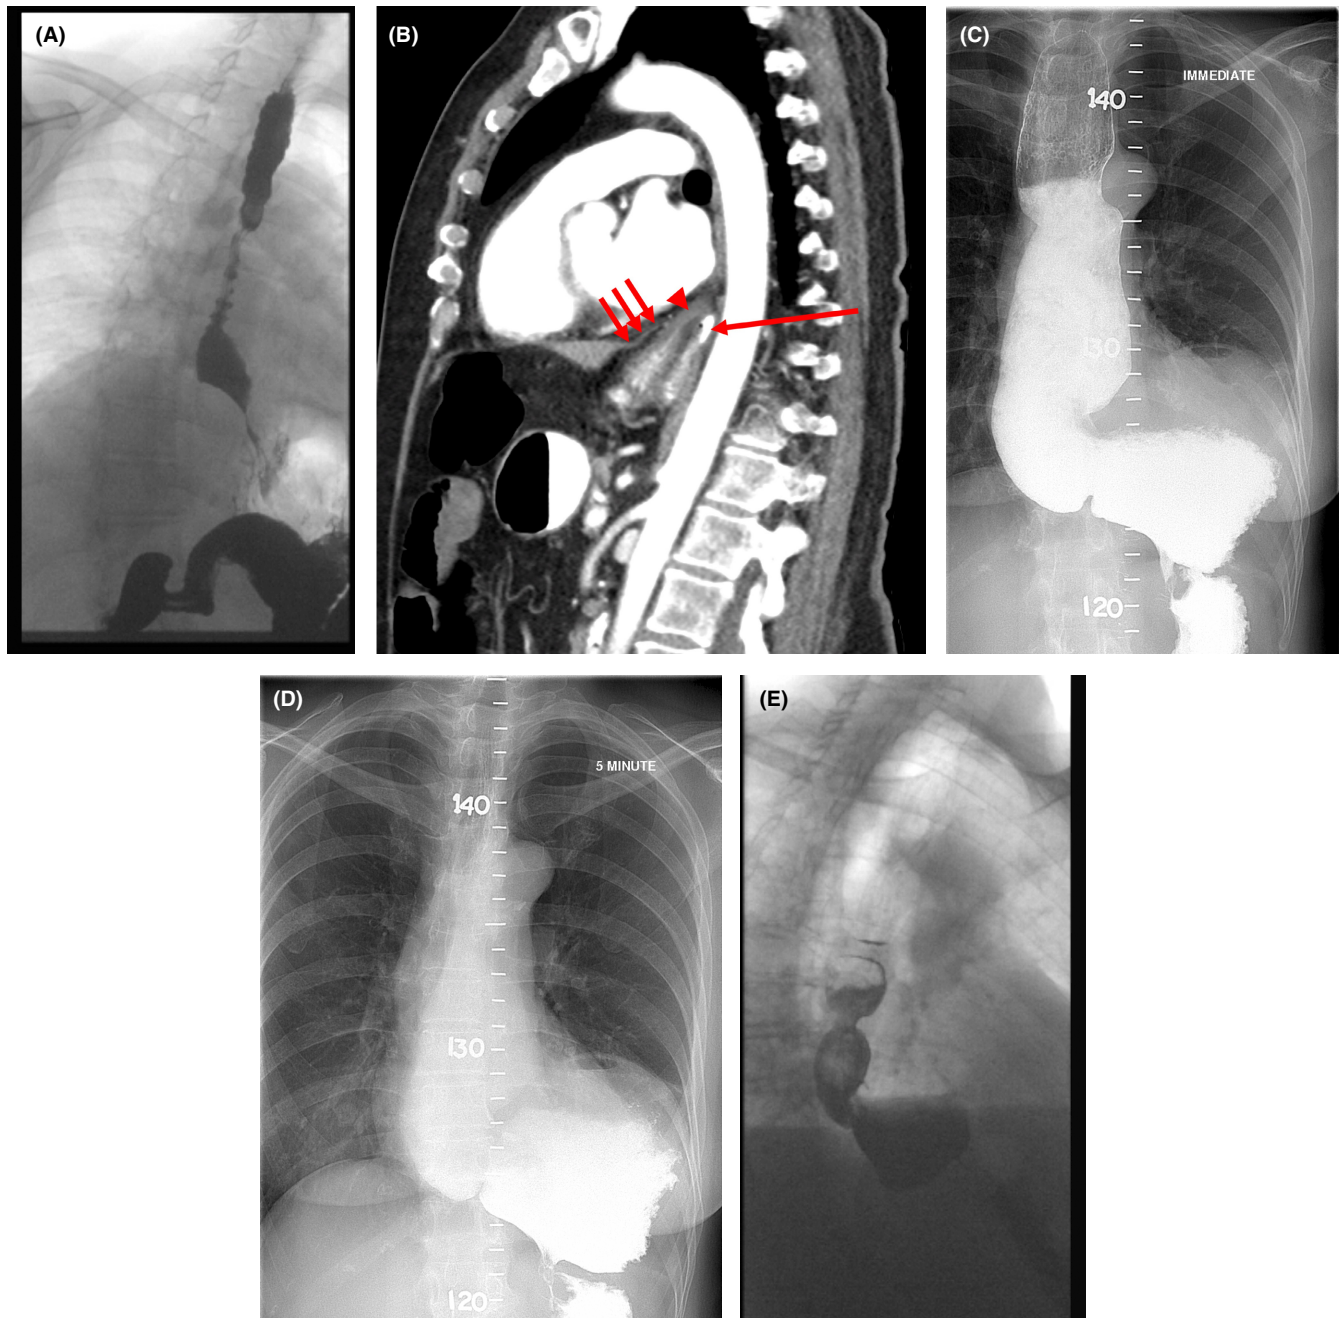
Barium swallow in assessment of symptom relapse after achalasia therapy. As well as assessing for true functional relapse of achalasia, barium swallow may identify other structural disorders leading to recurrent symptoms such as slippage of the post-myotomy fundoplication (A), distal esophageal sump (C, D), or diverticulum (E) formation. In (A), barium swallow demonstrates a persistent esophageal barium column terminating abruptly and coincident with a smooth rounded impression on the distal esophagus; CT scan following oral and intravenous contrast (B) confirms that this impression is indeed due to a migrated wrap (arrowhead) clearly seen superior to the diaphragm (short arrows), and compressing the oral contrast in the esophagus (long arrow). (C) demonstrates timed barium swallow immediately after ingestion of 200 mL barium in a patient 30 years post Heller myotomy. A grossly dilated, S-shaped sigmoid esophagus with tall column of contrast in the esophagus is demonstrated. After 5 min (D), most of the vertical column has drained but contrast remains in the baggy “sump,” much of which lies lower than the esophago-gastric junction. Fluid and food may continue to pool in such a sump despite adequate disruption of the lower esophageal sphincter, and may be a cause of persistent symptoms. (E) demonstrates an epiphrenic diverticulum.
